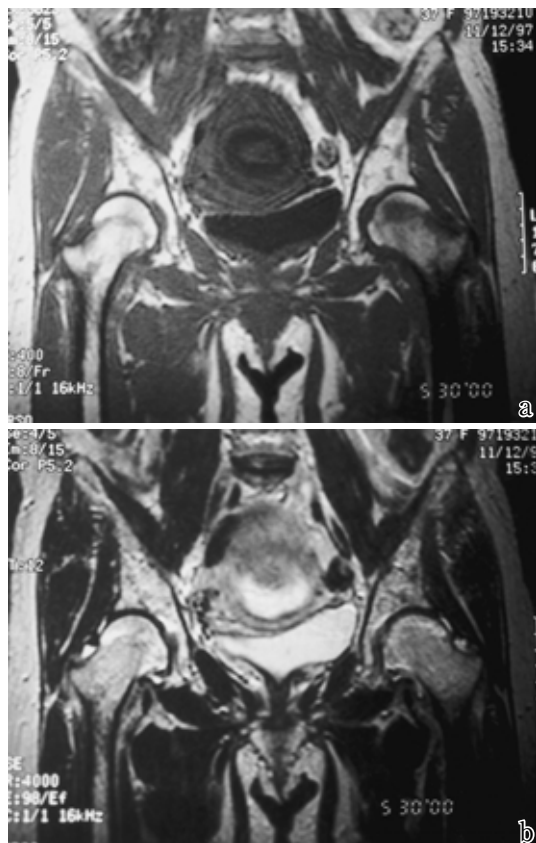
MRI findings at first visit (case 2)
